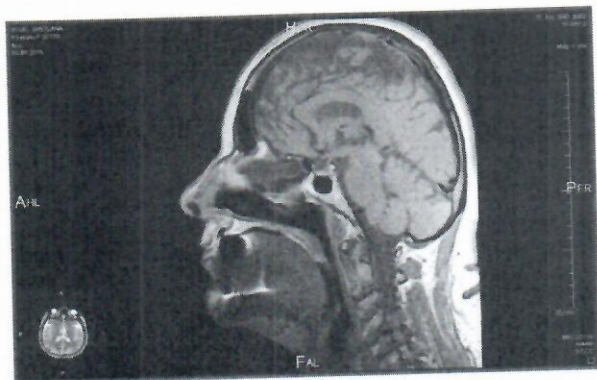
MRI - Volume of the pharynx before therapy.
